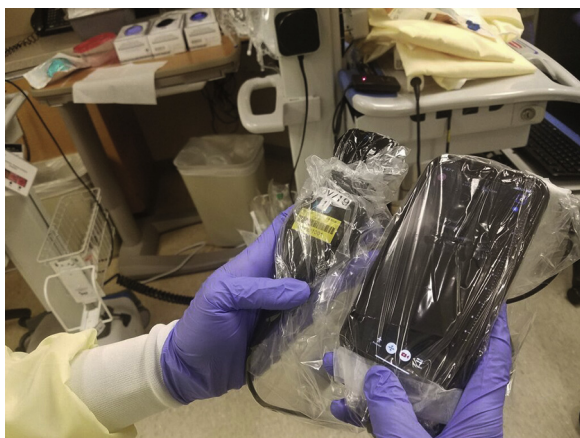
A portable handheld ultrasound probe and smartphone interface sheathed in a standard ultrasound probe cover.
